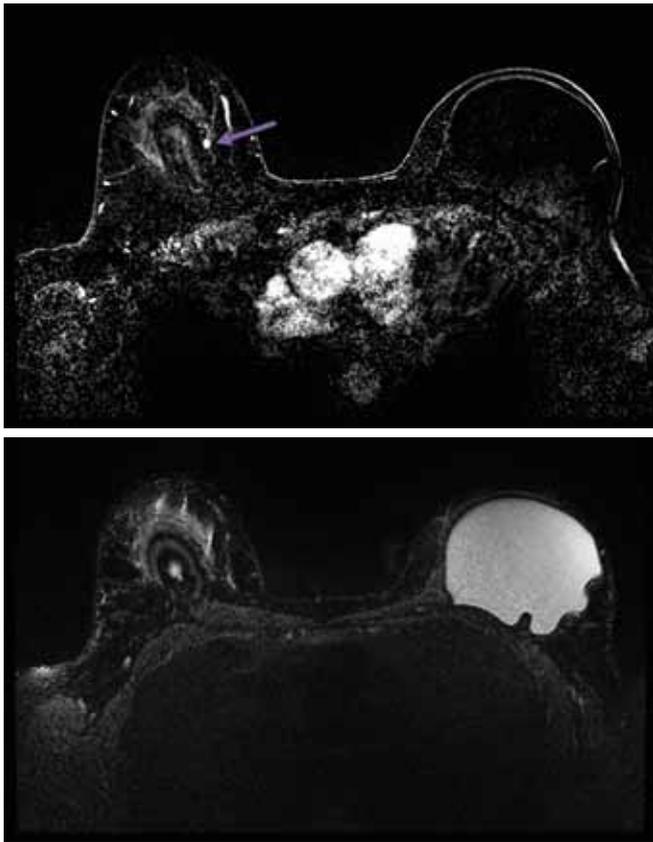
48 year-old woman with known BRCA1 mutation and a remote history of left breast cancer status post left mastectomy 10 years prior. Axial early subtraction series shows a 3mm enhancing mass in the right breast 1 o'clock position (arrow). On corresponding fast T2 weighted fat saturated image at the same slice location, the lesion is isoechoic and undiscernible. MRI-directed ultrasound-guided needle biopsy showed invasive ductal cancer, ER, PR and HER2 negative (triple-negative).
